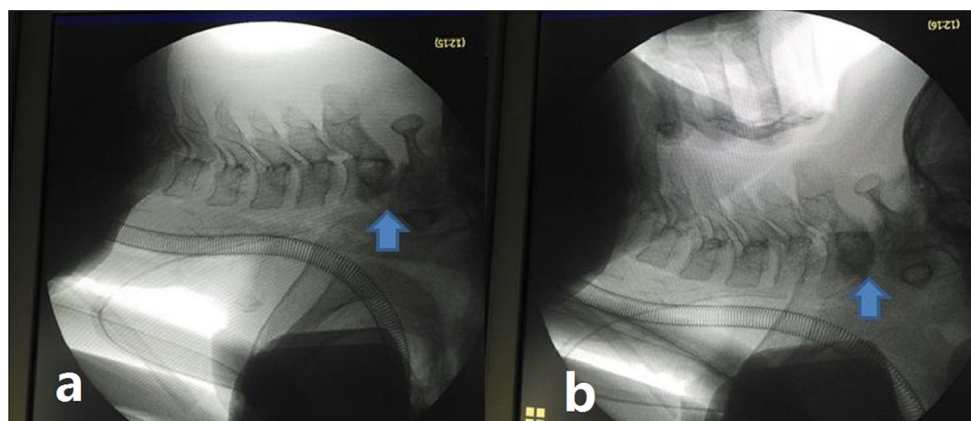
Anterior submandibular retropharyngeal odontoid osteotomy and posterior atlantoaxial fusion were performed. The osteotomy starting point and direction were determined through intraoperative fluoroscopy (a), and a high-speed burr (b) and ultrasonic bone curettage (c) were used for osteotomy
